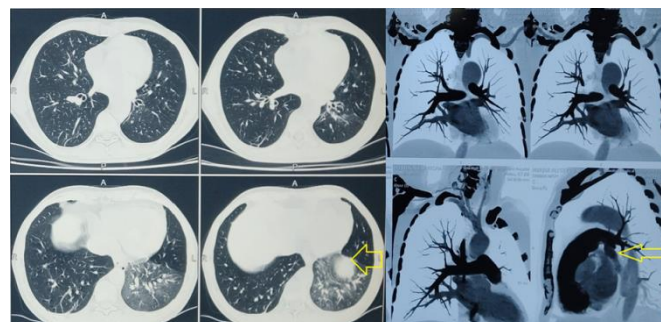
CECT Thorax and CT pulmonary angiography showing left lower lobe alveolar haemorrhage and left ectatic bronchial artery
